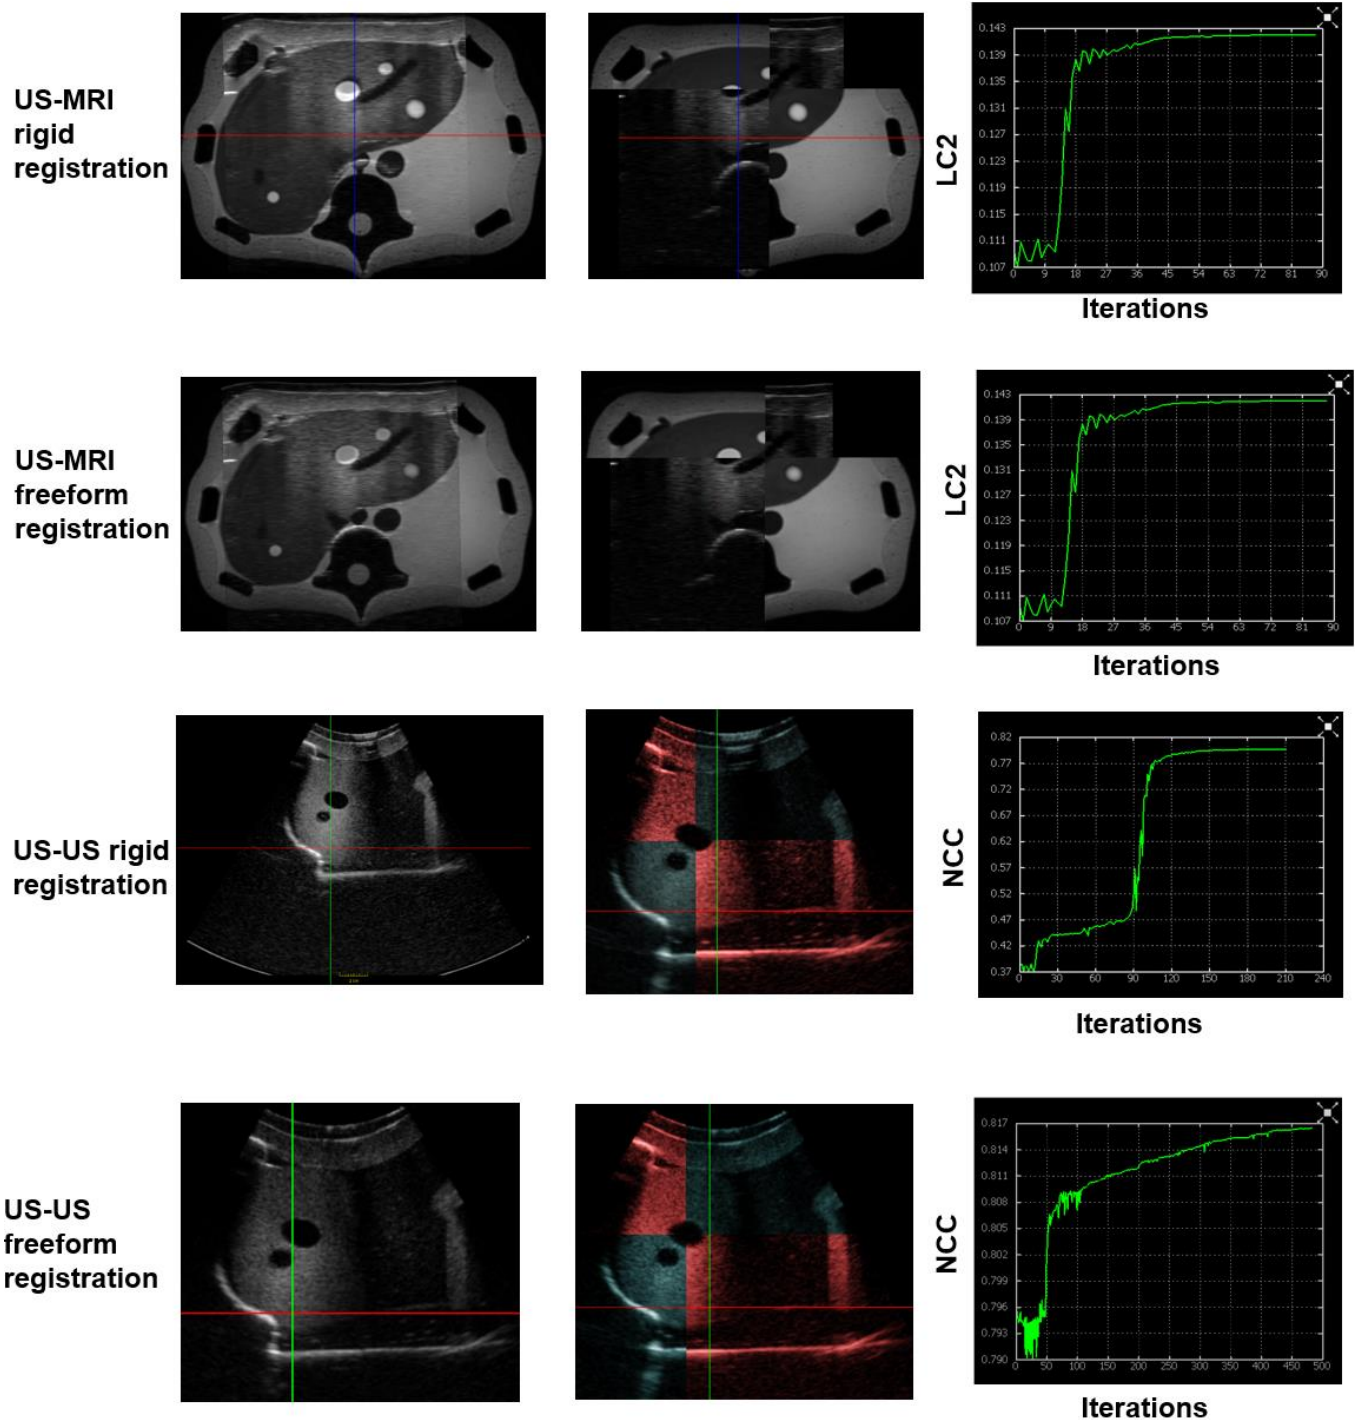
Experimental results of visual servoing with US-MRI and US-US registration, with both freeform and rigid registration. The photos depict the registration of the ultrasound image and the volume of interest once the robot has moved to its final position. The left photo shows both photos combined, and the right photo shows the current ultrasound volume in the lower left/upper right and the volume of interest in the upper left/lower right. Visual servoing accuracy is quantified using the linear correlation of linear combination (LC2) metric [6] for US-MRI and normalized cross correlation (NCC) metric for US-US.
